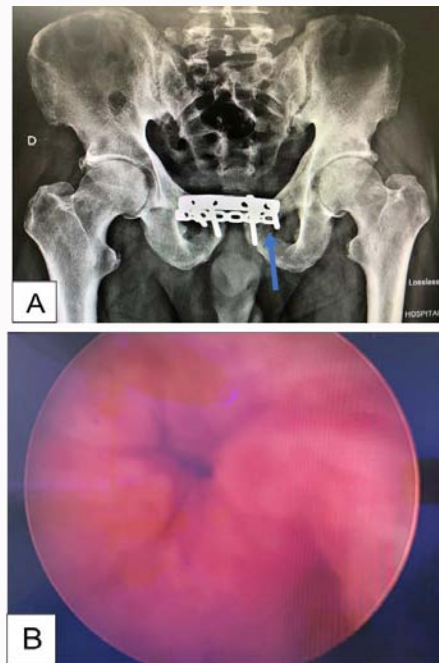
A) X-ray of the pelvis without the screw (arrow); B) Image of the fistula in the bladder.
